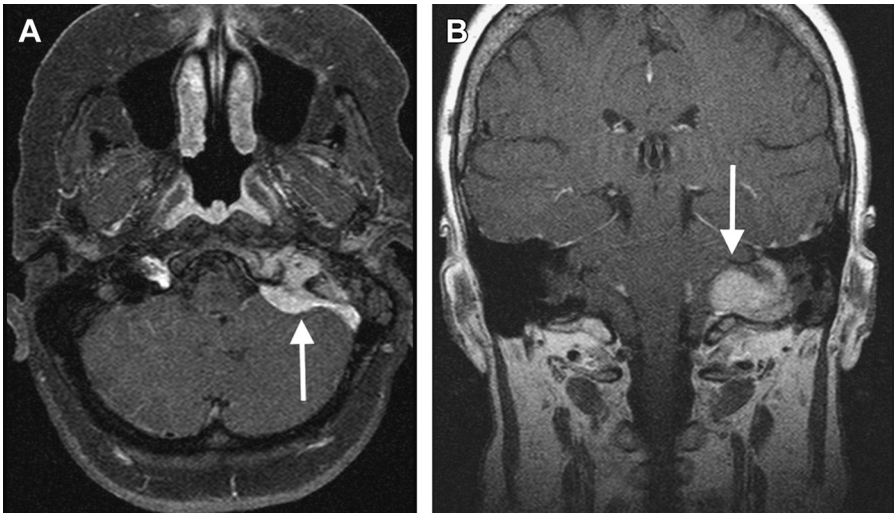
(A) Axial cut of a T1 MRI with contrast showing a left jugular foramen meningioma. The tumor is designated by the white arrow. (B) Coronal cut of a T1 MRI with contrast showing a left jugular foramen meningioma. The tumor is designated by the white arrow.
